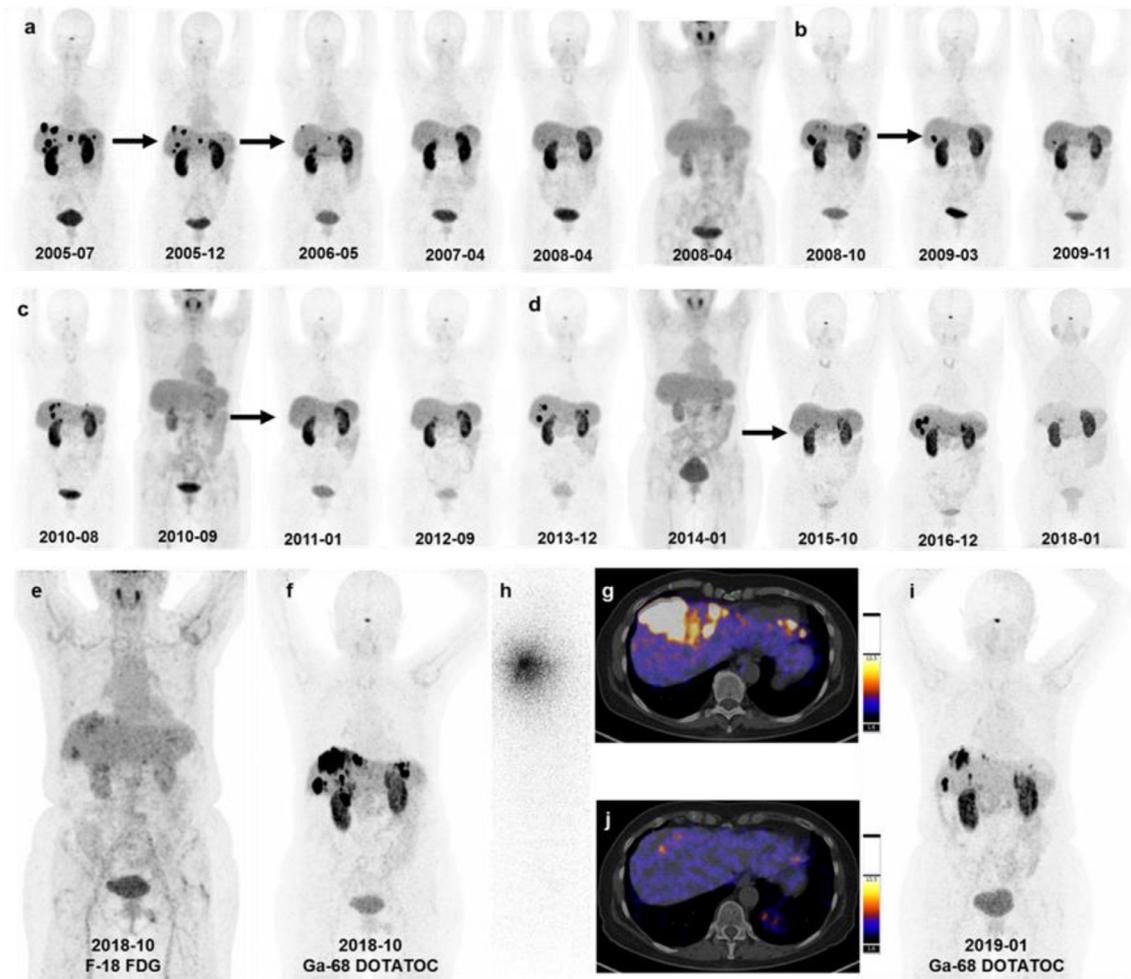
A 50-year-old woman was diagnosed in 1999 with a pancreatic neuroendocrine neoplasm with hepatic metastases. Ga-68 DOTATOC PET/CT showed intense somatostatin receptor expression in the primary tumor and multiple hepatic metastases. Pancreatectomy, splenectomy, lymph node dissection, and partial liver resection were performed. The patient was then treated between 2002 and 2014 with eight cycles of peptide receptor radionuclide therapy, using both Y-90 and Lu-177 (DUO-PRRT); the cumulative administered radioactivity was 44.5 GBq (a-d). In 2017, relaparotomy, radiofrequency thermoablation, and transarterial chemoembolization were performed with mixed response. Severe progression with multiple hepatic metastases occurred in October 2018 (f, g), when increased glycolysis (FDG uptake) was also demonstrated in some of the hepatic lesions (e). The patient was then treated by intra-arterial α -radiation therapy using 8.4 MBq Ac-225 DOTATOC (h). The treatment was well tolerated, no adverse effects were noted during IA-ART and in follow-up. Three months later, a very good response (partial remission) was demonstrated by Ga-68 DOTATOC PET/CT (i, j) and MRI (not shown). No hematological toxicity, nephrotoxicity, or any liver dysfunction was observed.
